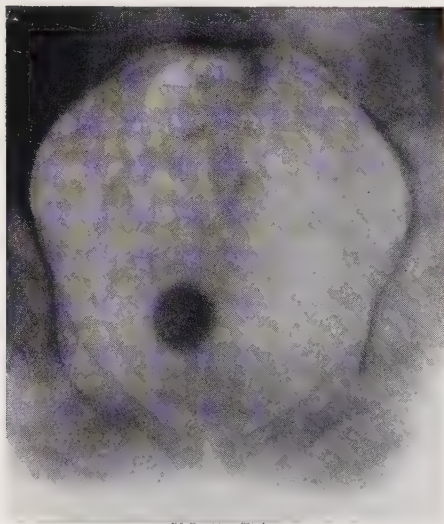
ANTHROPOID PELVIS; X-RAY OF INLET, SHOWING LONG ANTERO-POSTERIOR DIAMETER.
